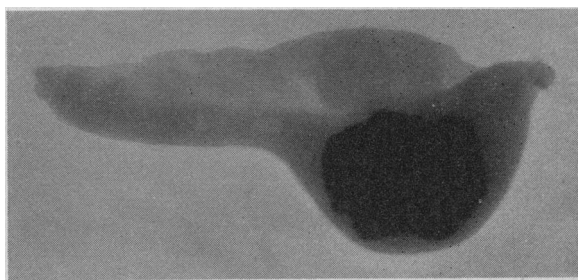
X-ray film of appendix immediately after removal.
